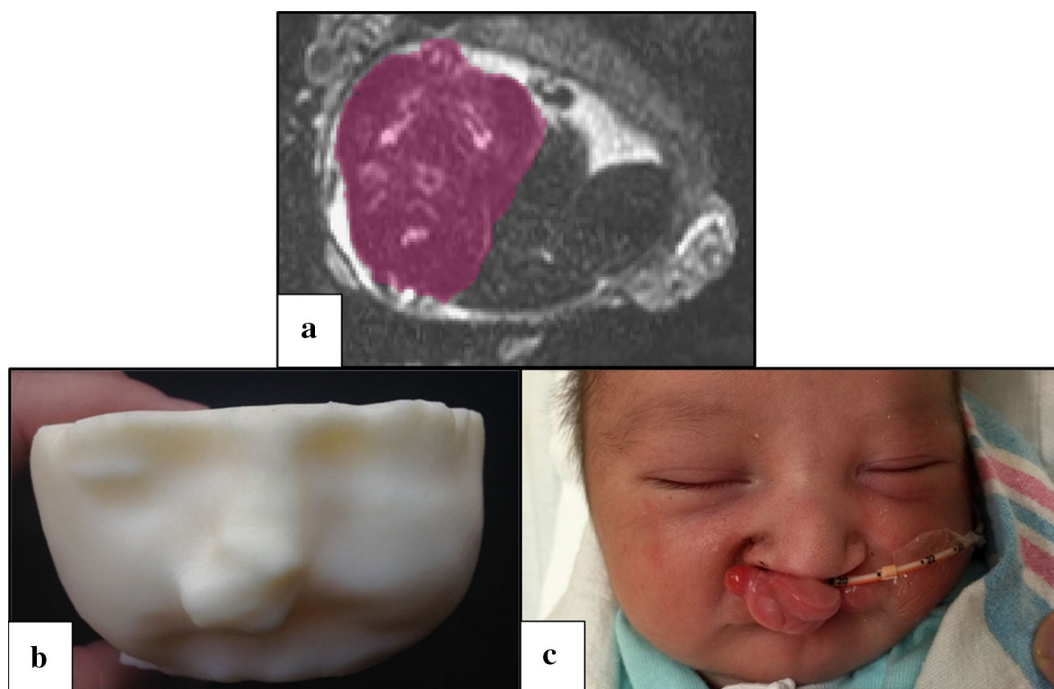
(a) MRI showing unclear evidence of airway obstruction in a fetus with known congenital malformation of the maxillofacial area; (b) Final 3-D-printed model that demonstrates an isolated upper lip soft tissue mass not involving the airway of the fetus; (c) Patient delivered successfully via cesarean section without need for emergency ex utero intrapartum treatment (EXIT) procedure given 3-D model demonstration of clear airway.
